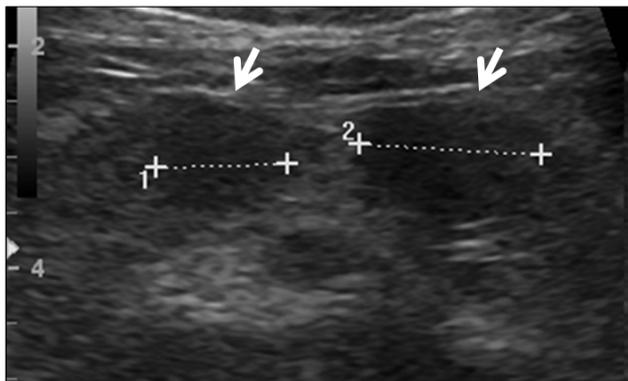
Abdominal ultrasonography revealing approximately 1.2 cm and 1.6 cm sized low echoic round lesions (arrows).
